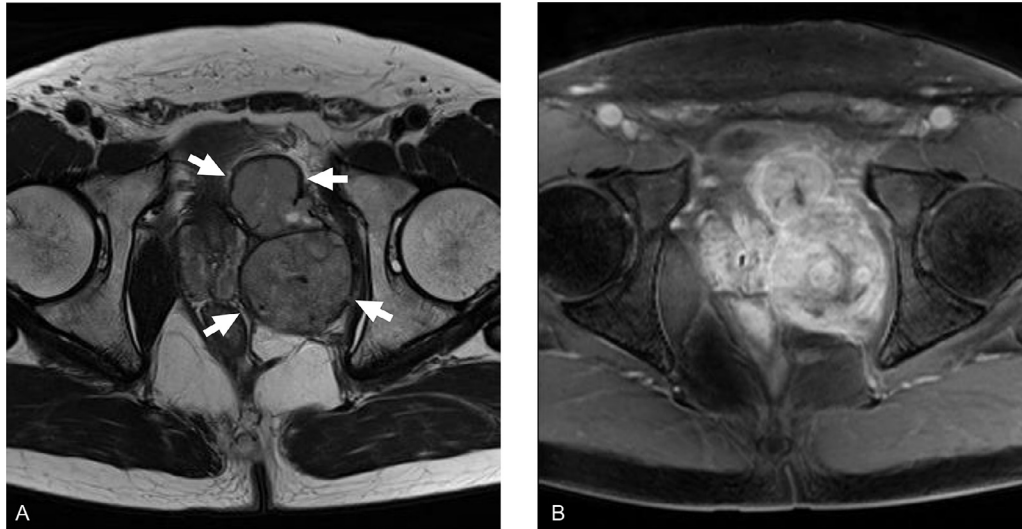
Axial view of T2-weighted magnetic resonance imaging (MRI) (A) revealed a lobulated mild high-intensity mass (white arrows). Axial view of fat-suppressed T1-weighted gadolinium contrast-enhanced MRI (B) revealed that the mass was well enhanced.
